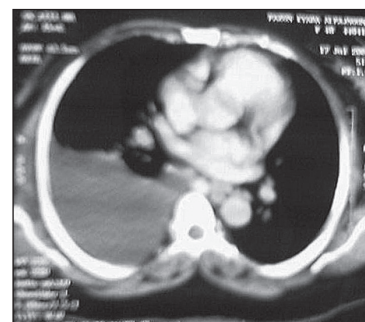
CT scan showing tuberculous pleural effusion before treatment.
